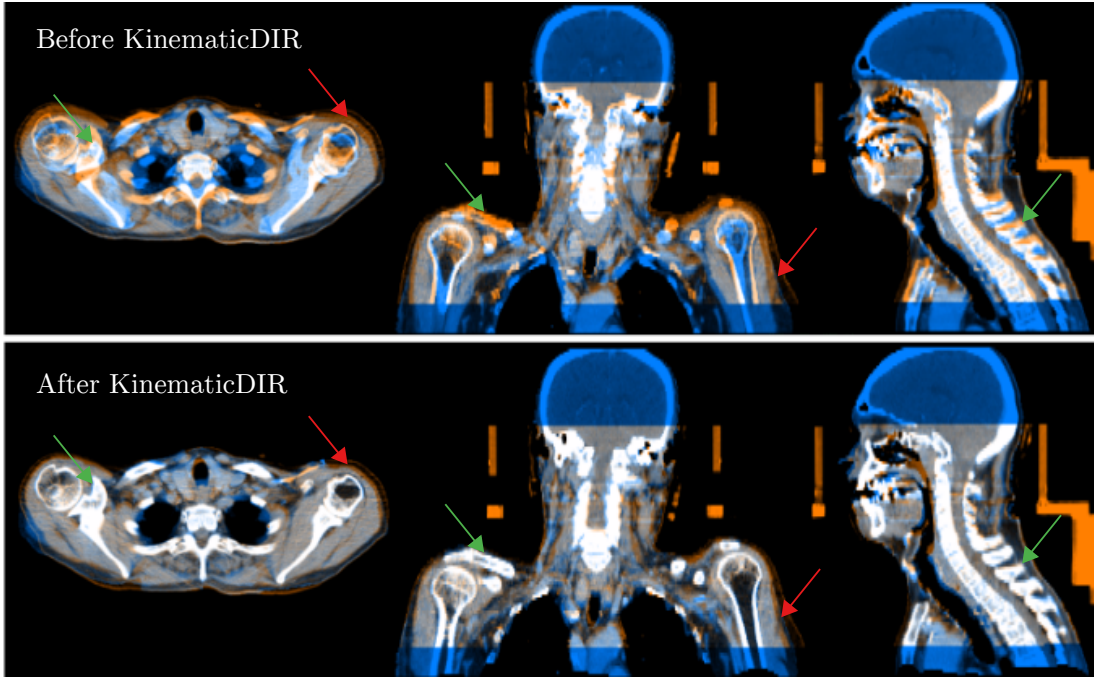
Visual evaluation of monomodal image registration with KinematicDIR. The upper row shows the transversal, frontal and sagittal slice of a color fusion before deformable image registration. planning CT (blue) and fraction CT (orange). The lower row displays the fusion after KinematicDIR. Green arrows indicate locations of excellent registration of bone tissue. Red arrows show residual soft tissue deformations.
